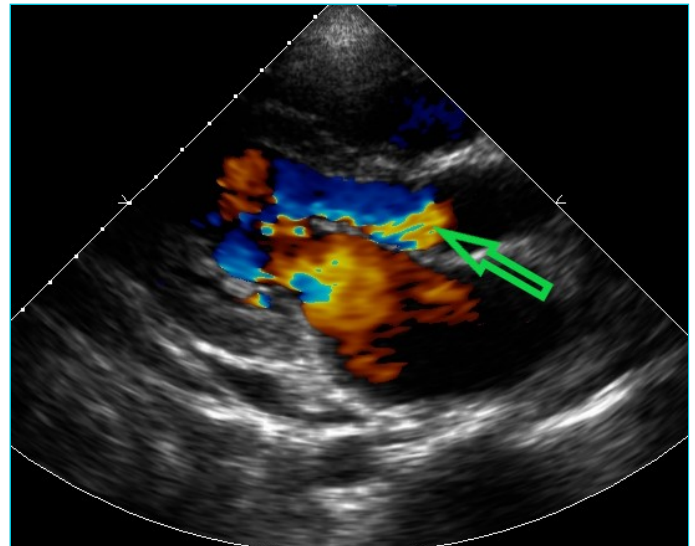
Heart valve dysfunctions in initial echocardiography
